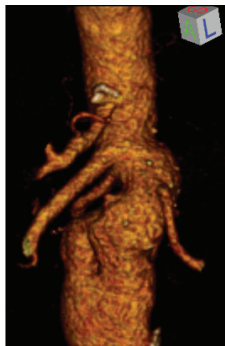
Preprocedural CT scan showing a challenging renal/visceral segment with a narrow aortic lumen not amenable to outer branches.
